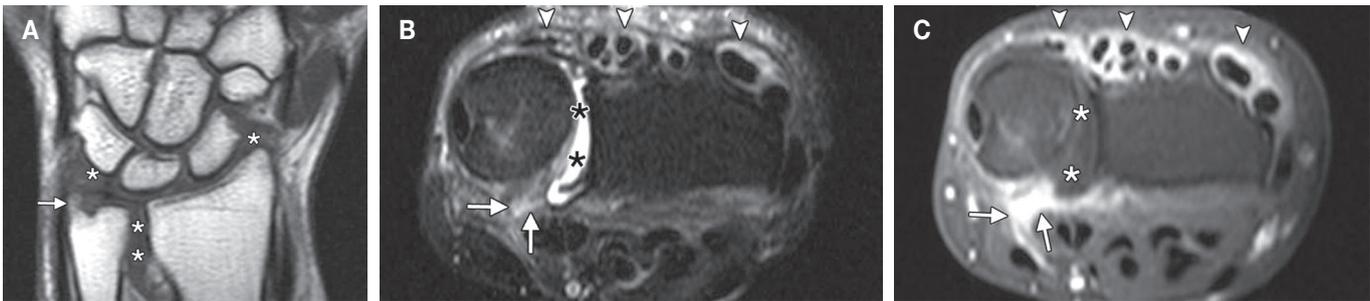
Synovitis early rheumatoid arthritis of the wrist (4 months duration) and inconclusive radiographic findings. (a) Coronal T1-w MR image shows intermediate-signal-intensity tissue in the radiocarpal, radioulnar, and ulnocarpal joints (*). An ill-defined hypointense area in the ulnar styloid process (arrow) represents bone marrow edema. (b) Axial fat-suppressed, heavily T2-w MR image shows hyperintense tissue in the radioulnar joint cavity (*), a finding that corresponds to joint fluid. Note also the intermediate signal intensity of the synovial thickening of the volar aspect of the radioulnar joint (arrows) and of the tendon sheaths of the second to fifth extensor compartments (arrowheads). (c) On an axial contrast material-enhanced fat-suppressed T1-w MR image, the radioulnar joint cavity is unenhanced (*), a finding that corresponds to joint fluid. However, the synovial thickening seen in b is now markedly enhanced (arrows and arrowheads), a finding that corresponds to acute synovitis.
